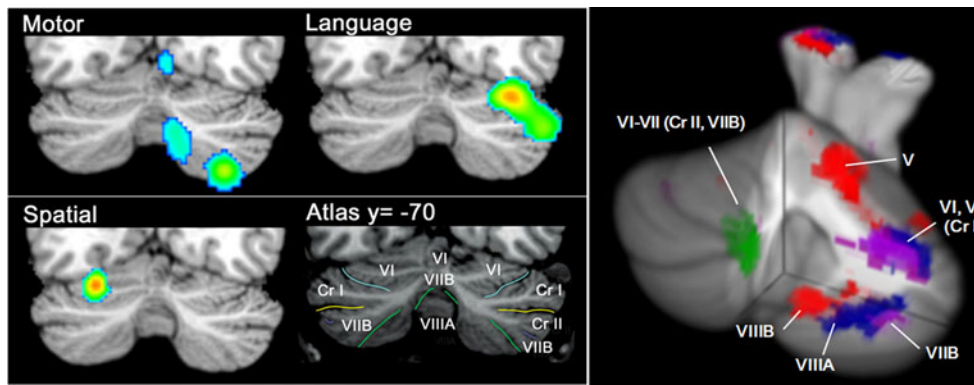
Functional topography in the human cerebellum. Segregated “motor” (lobules I–V and VIII) and “cognitive” (lobules VI and VII) areas of the cerebellum based on functional MRI data. *Left*, Meta-analysis of functional MRI studies shows converging activation for
